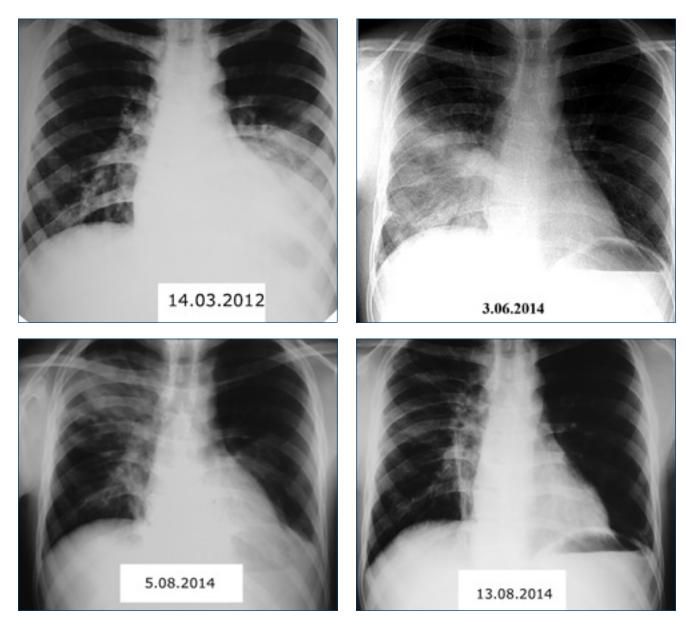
Chest radiographs confirming recurrent pneumonias with variable lobar distribution in the previous years
